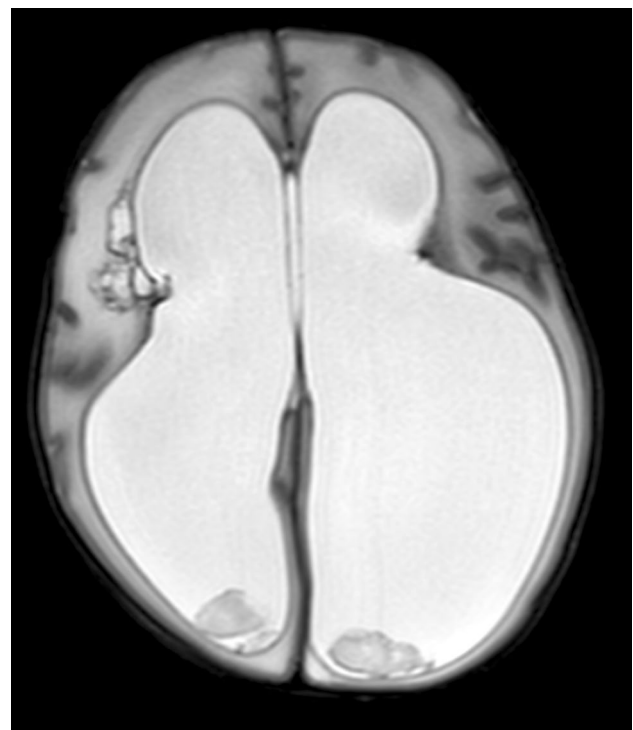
Axial T2-weighted MRI demonstrating hydrocephalus secondary to Papile Grade IV intraventricular and intraparenchymal haemorrhage
